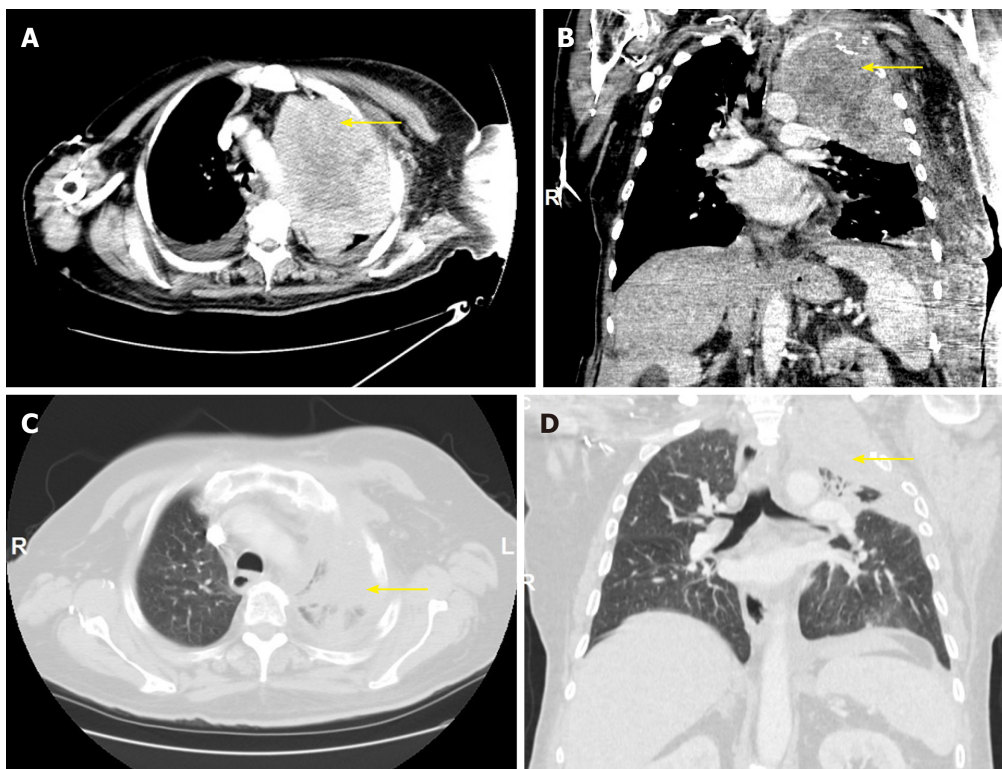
Chest computed tomography. A, B: Prior to initiation of pembrolizumab, with yellow arrows pointing to a left upper lobe primary measuring 14.1 cm × 10.6 cm × 14.9 cm. C, D: After 5 cycles of pembrolizumab, with yellow arrows pointing to a markedly decreased left upper lobe mass measuring 8.0 cm × 7.7 cm × 6.8 cm.
